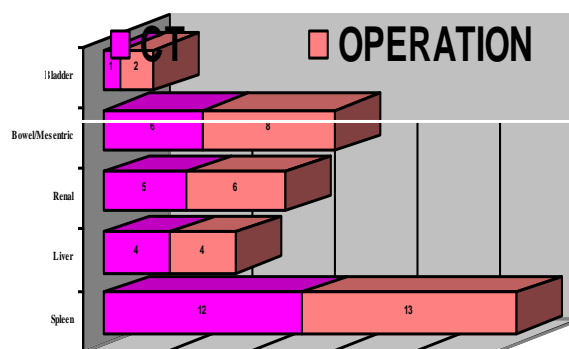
Frequency of visceral injuries detected on CT and Operation (n=30)
